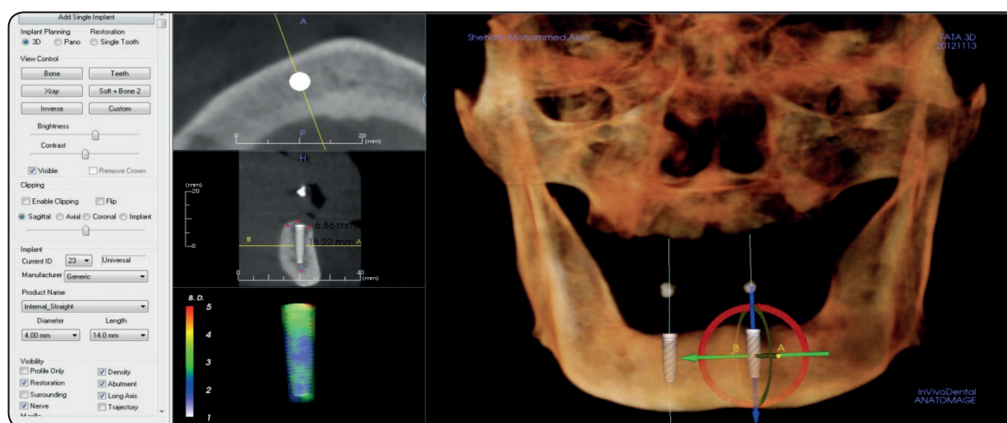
Pre-operative CBCT to determine the suitable size of the implant showing bone height, width, and density at the planned implant site.
